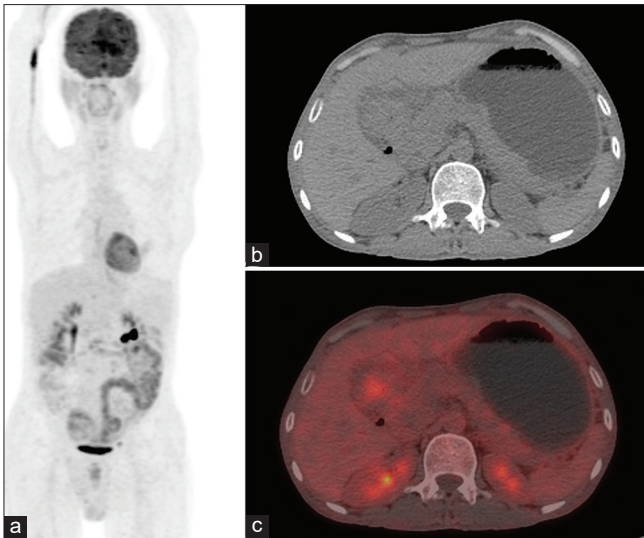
Case of 52-year-old male who presented with features of gastric outlet obstruction and was referred for 18F-FDG positron emission tomography/computed tomography for baseline evaluation (MIP [a], Axial computed tomography [b], Axial positron emission tomography/computed tomography [c]). Positron emission tomography/computed tomography showed a circumferential thickening involving the distal pylorus (b) and gastro-duodenal junction, but showing minimal to mild FDG uptake (a and c). The patient was later diagnosed as having Signet cell adenocarcinoma of the stomach, which have not been shown to be very 18F-FDG avid
